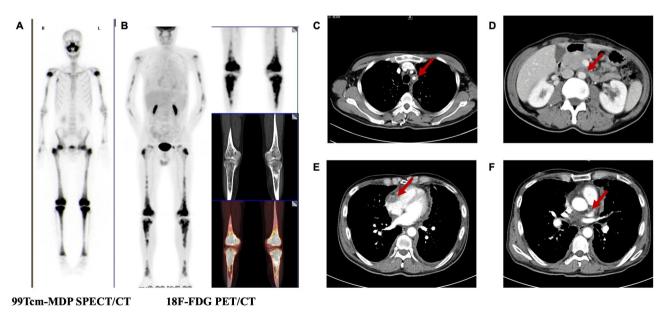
Comprehensive Imaging Profile of the Patient. (A) Bone scintigraphy showed increased radioactive uptake in the nasal bones, maxilla and bilateral symmetric long bones of the limbs. (B) 18 F-FDG PET/CT revealed multiple areas of increased metabolism in the long bones of the limbs. Thoracoabdominal enhanced computed tomography (CT) showed (C) circumferential wall thickening and lumen narrowing at the root of the left subclavian artery, (D) uneven thickening of the aortic wall, (E) soft tissue shadows in the right atrioventricular groove and (F) soft tissue shadows in the anterior descending branch area of the heart
